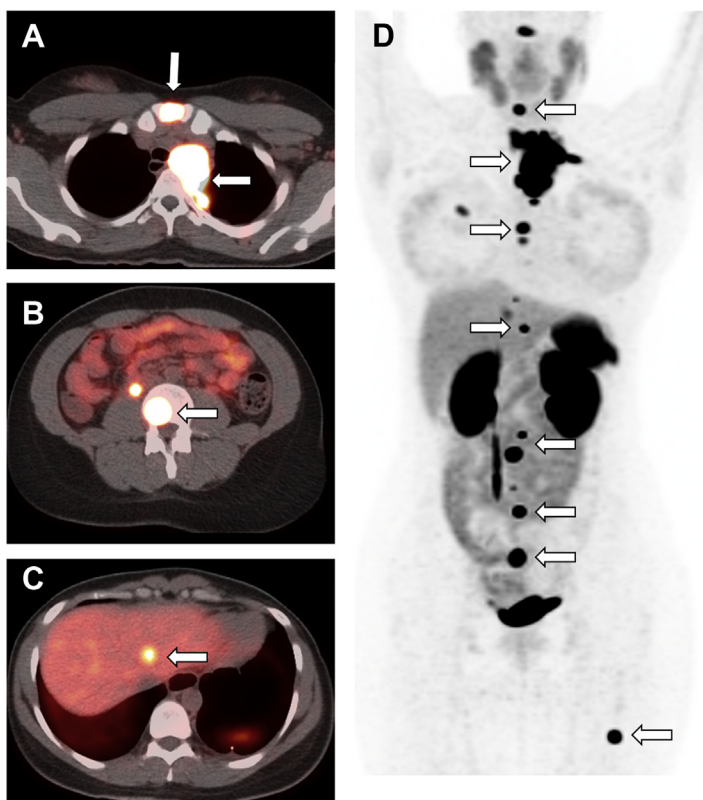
Axial fused [^{68}Ga]DOTATATE-PET/CT (A–C) and maximum intensity projection image (D) in a patient with metastatic paraganglioma. Metastases (arrows) are present in the sternum, upper mediastinal and cervical lymph nodes, spine, liver, right, and left femur.
